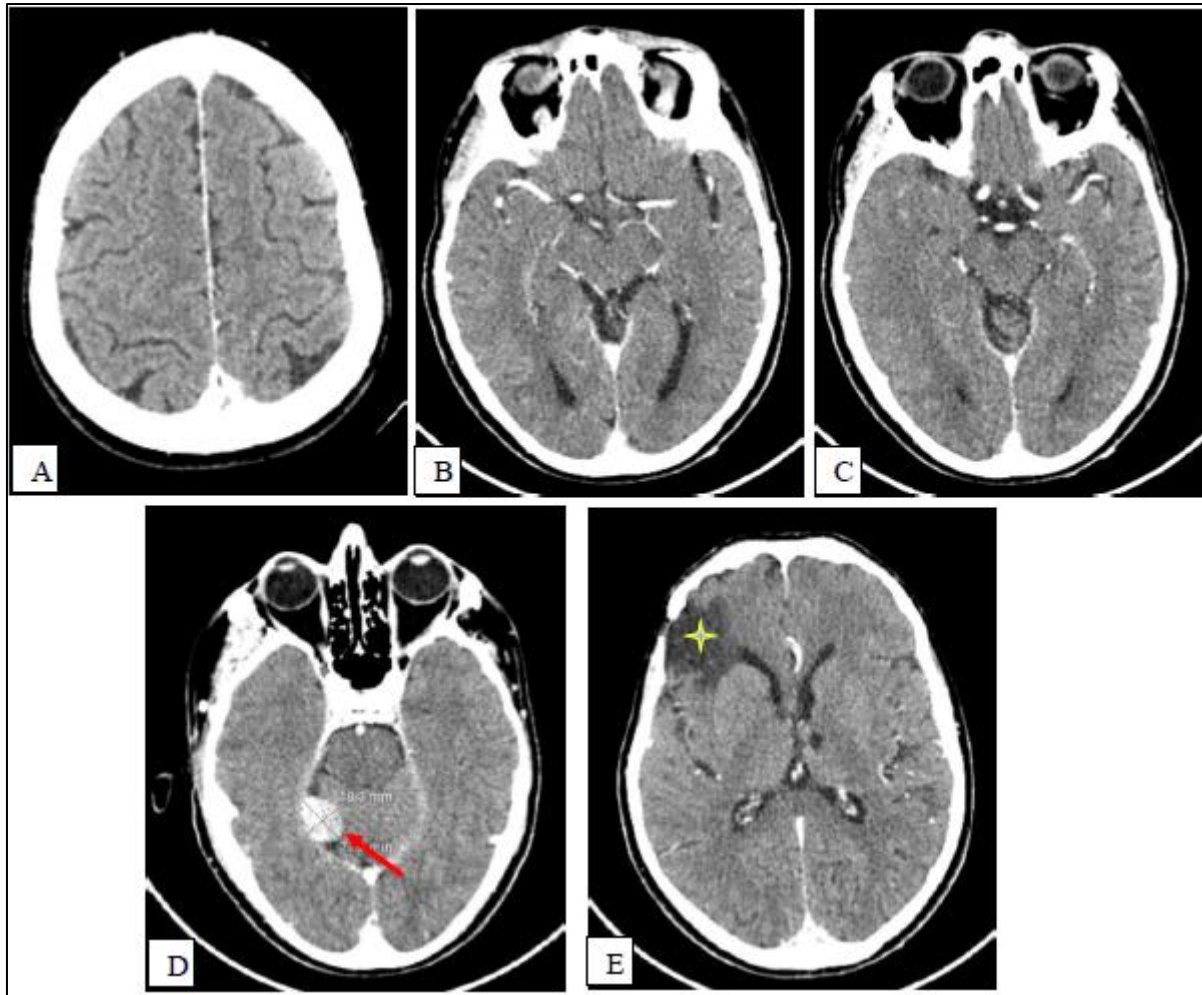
Follow-up contrast-enhanced brain CT (axial views, same levels as Figure 1). Compared with baseline, there is a marked radiological response with complete resolution of three previously described lesions (A–C). The remaining extra-axial lesion along the right cerebellar tentorium shows partial regression (D), now measuring approximately 18 × 23 mm in axial dimensions (red arrow). The right fronto-subcortical hypodense area (E, yellow star) persists, consistent with postoperative changes.
